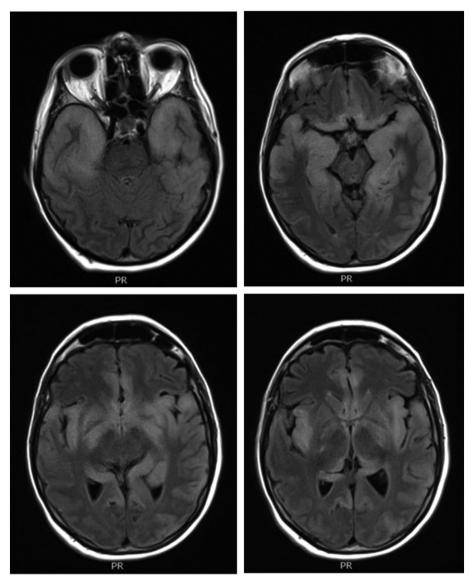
Brain MRI. FLAIR weighted sequences showing diffuse high signals in the limbic system extending in the pallidum, the sub-thalamic region and the occipital lobe.
